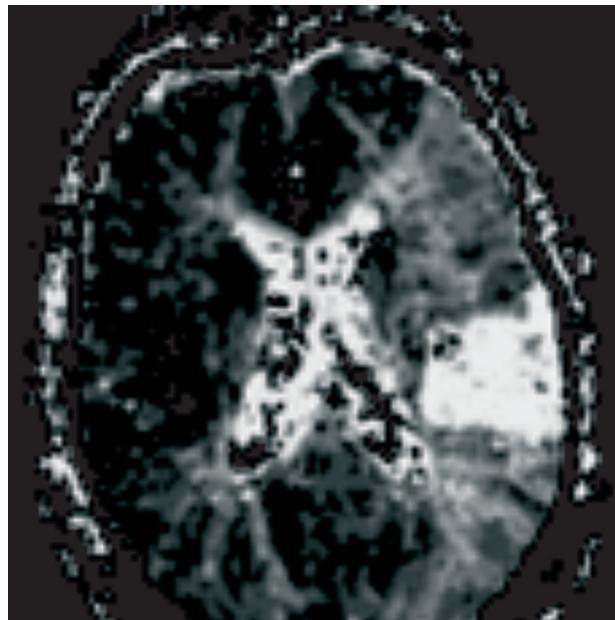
MRI perfusion of CVI
